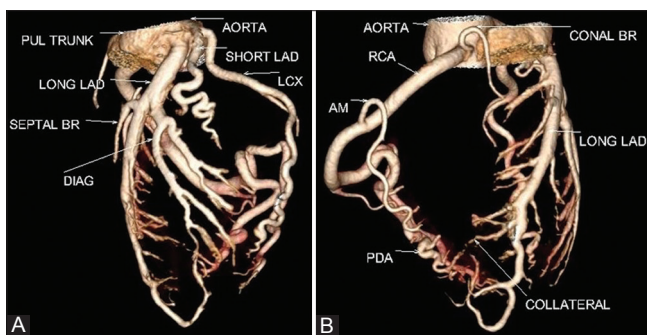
(A and B): (A and B) Segmented 3D CT image demonstrates the origin of RCA and LCA from the respective coronary sinuses, LCA terminating into short LAD and circumflex arteries and long LAD arising from the pulmonary trunk
